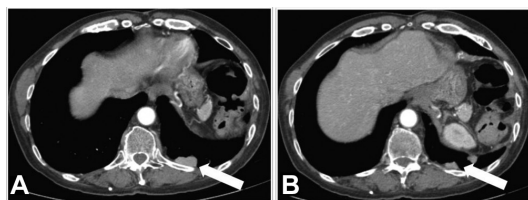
Contrast-enhanced axial CT images of the thorax shows three enhancing pleural based masses (white arrows in A and B) in the posterior left hemithorax.
